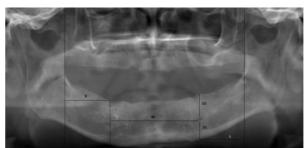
Vertical and horizontal distances measured on panoramic radiographs.
